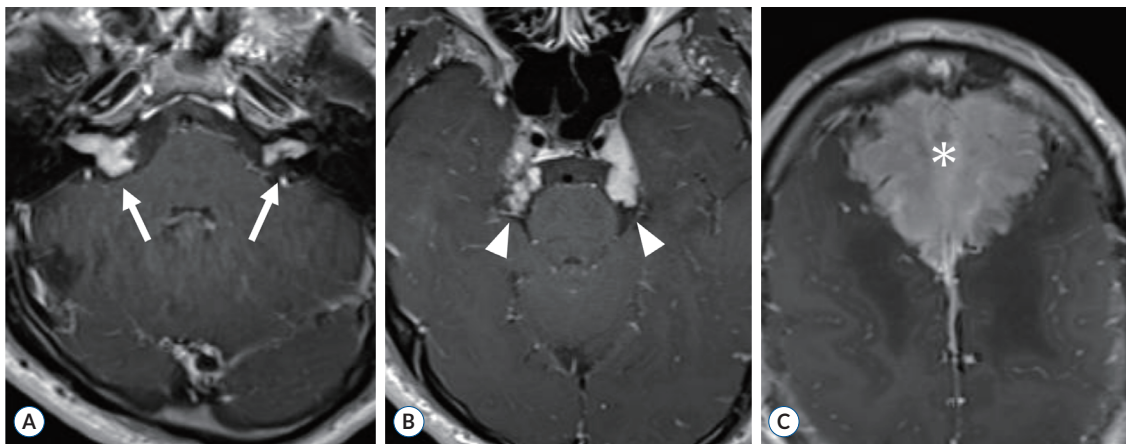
A 24-year-old male who came with seizures. The patient had past histories of neurofibromatosis (no details of the type) diagnosed by a biopsy of skin granules and a cervical spinal ependymoma removed at the age of 12 years. Axial T1-weighted contrast-enhanced brain-MRI presented bilateral vestibular schwannomas (arrows) (A), bilateral trigeminal schwannomas (arrowheads) (B), and a frontal parasagittal sinus meningioma (asterisk) (C). The meningioma was totally removed via surgery, whereas the bilateral schwannomas were periodically observed by MRI. MRI : magnetic resonance imaging.
